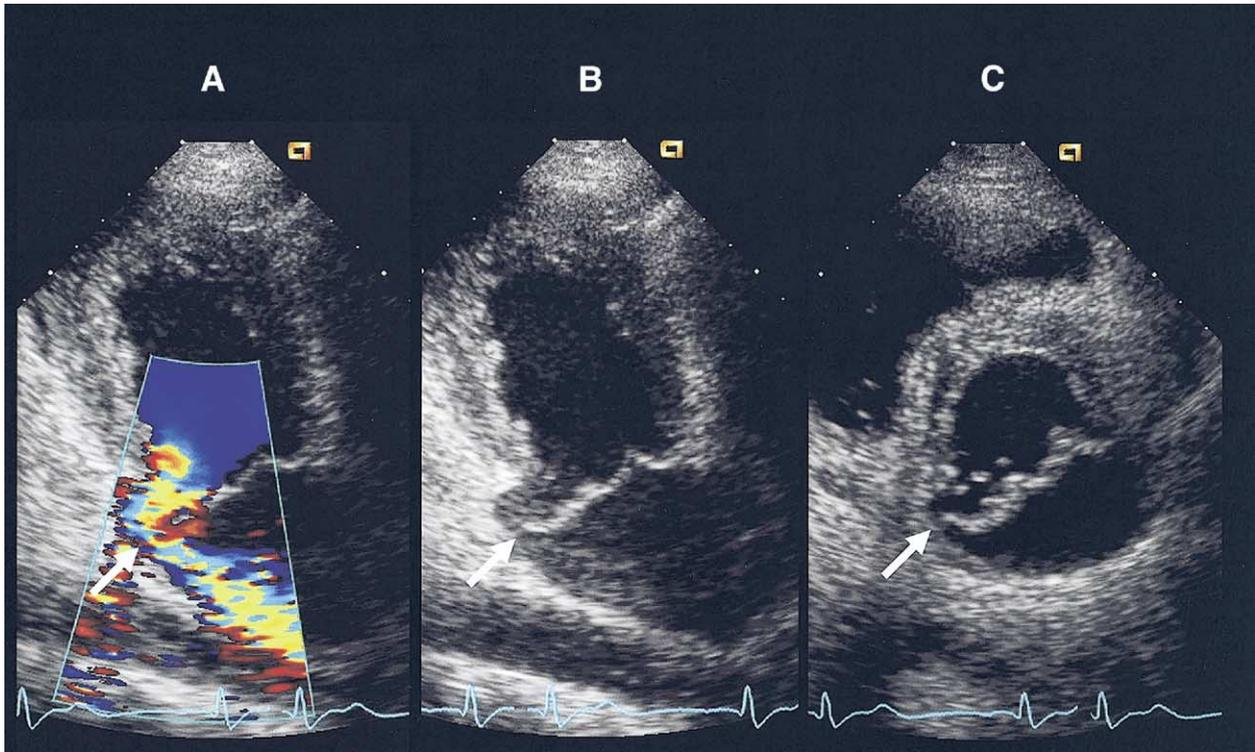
Posterior commissural prolapse. Eccentric regurgitant jet (A) resulting from a commissural discontinuity (arrows) seen in the intercommissural plane (B) and parasternal short-axis view (C).
